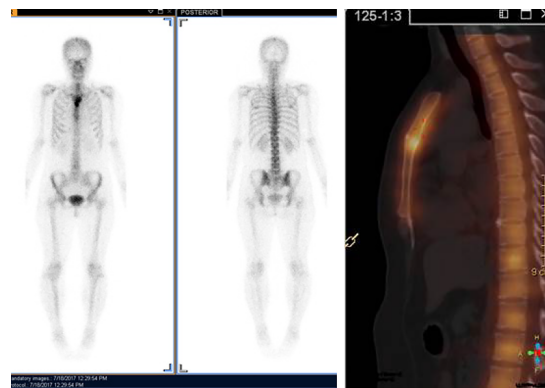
Bone scintigraphy scan with Tc^{99m}-MDP. Apparent fixation of the radiopharmaceuticals in the manubrium sternum and upper segment of the body of the sternum. No involvement of other sites of the skeleton was found.
